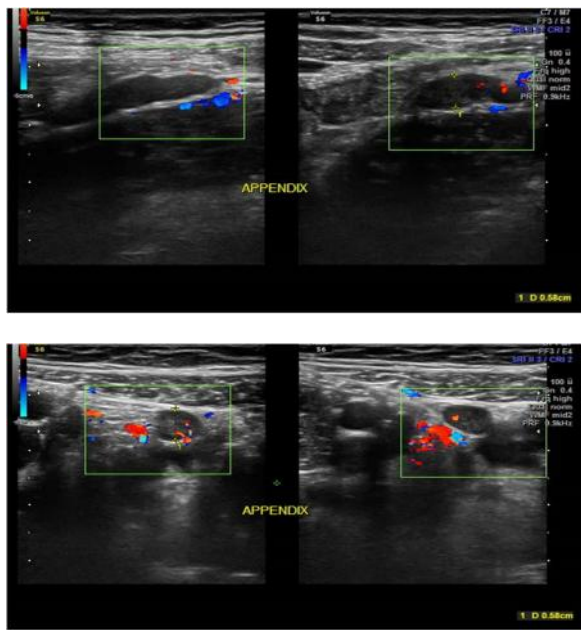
(C,D). Longitudinal & Transverse sonogram of the right lower quadrant in a 11 years old female child reveals border line enlarged appendix of thickness 5.8mm (Grade 4).
